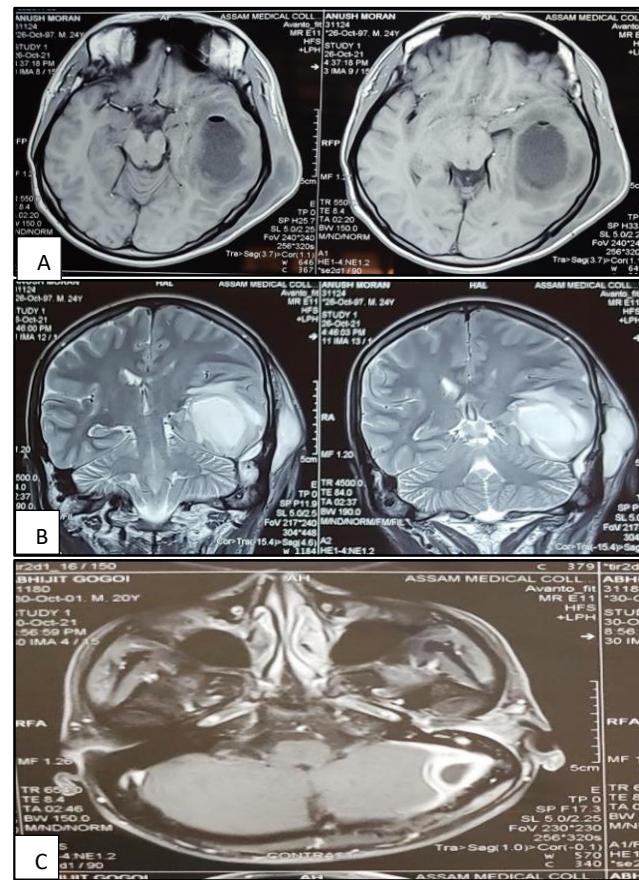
(A-C): MRI brain of left temporoparietal abscess (Axial cut) and left temporoparietal abscess (Coronal Cut) and left extradural cerebellar abscess (Axial cut).
